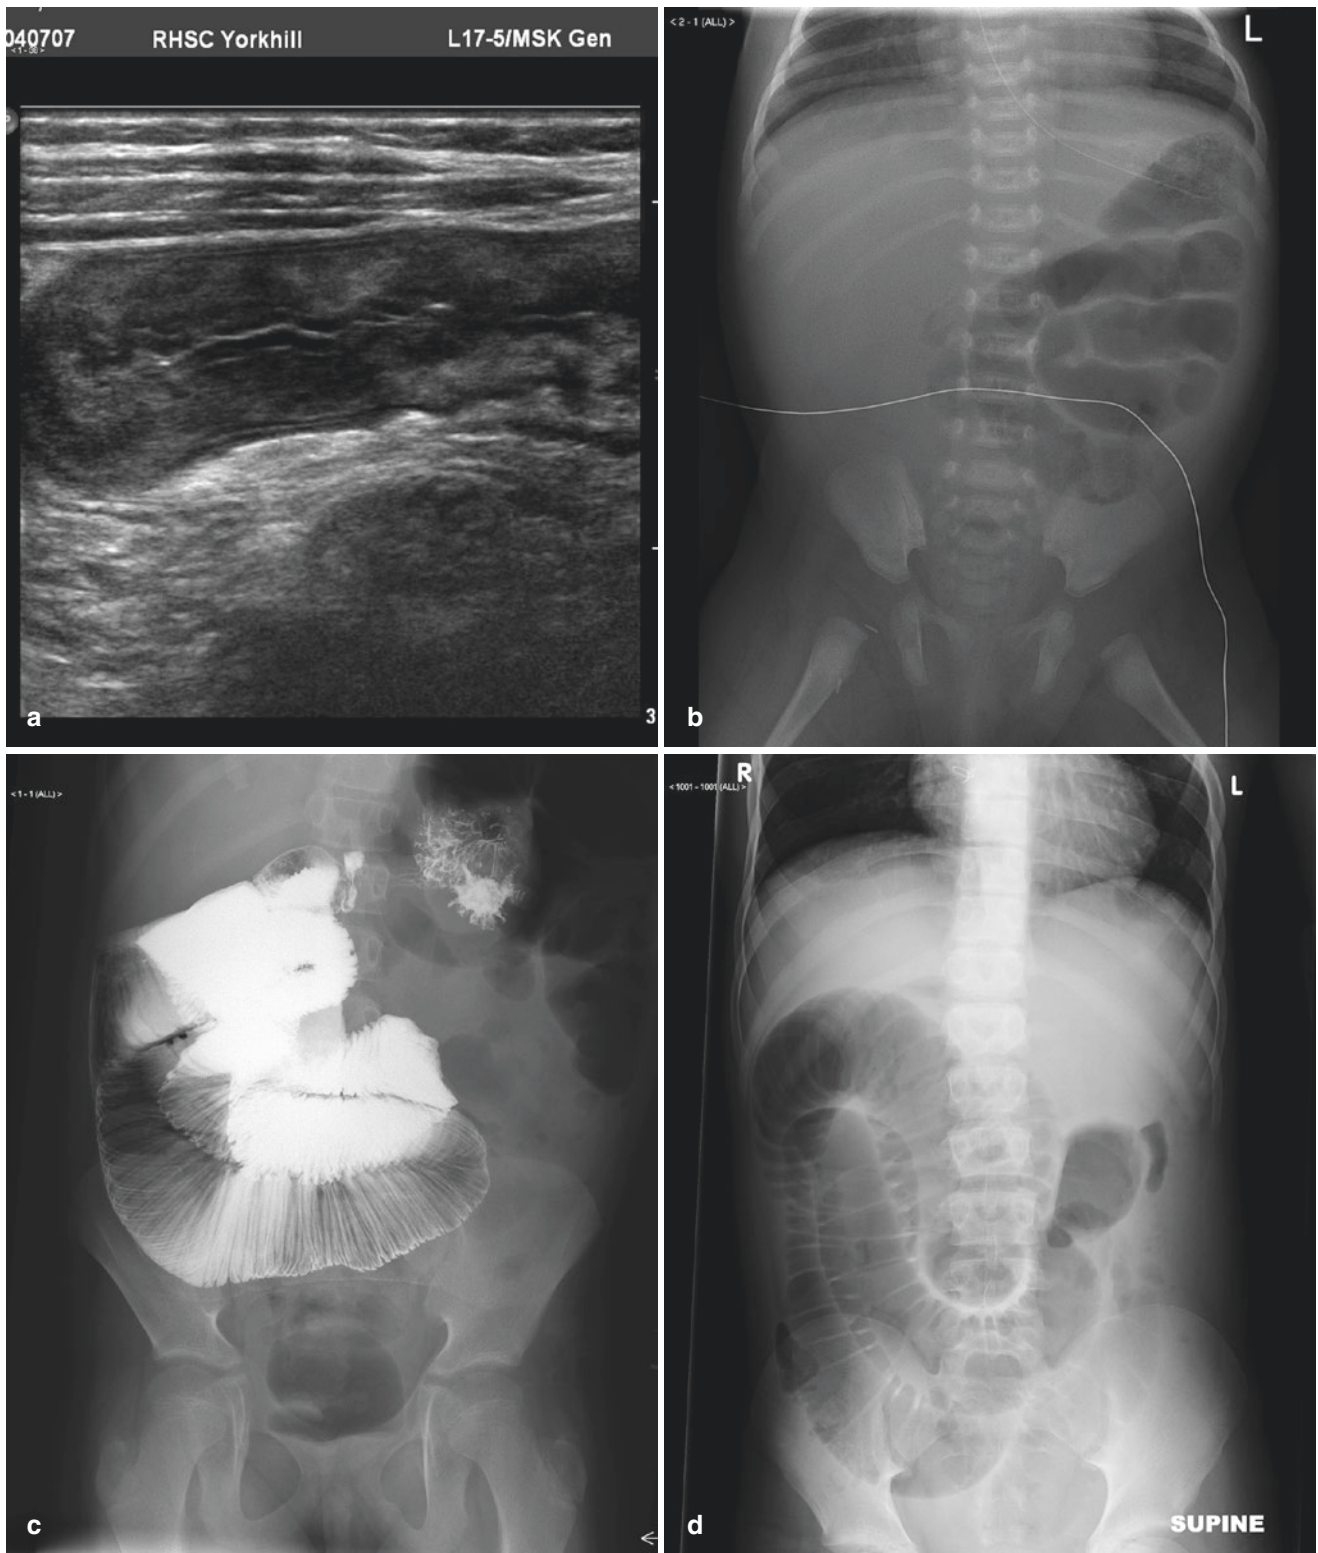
(a) Ultrasound demonstrating loops of bowel below the surface of the abdominal wall. (b) Adhesion obstruction of the small bowel showing dilated isolated loops of bowel on the left side and no gas in the rest of the abdomen. (c) Small bowel obstruction, contrast seen
